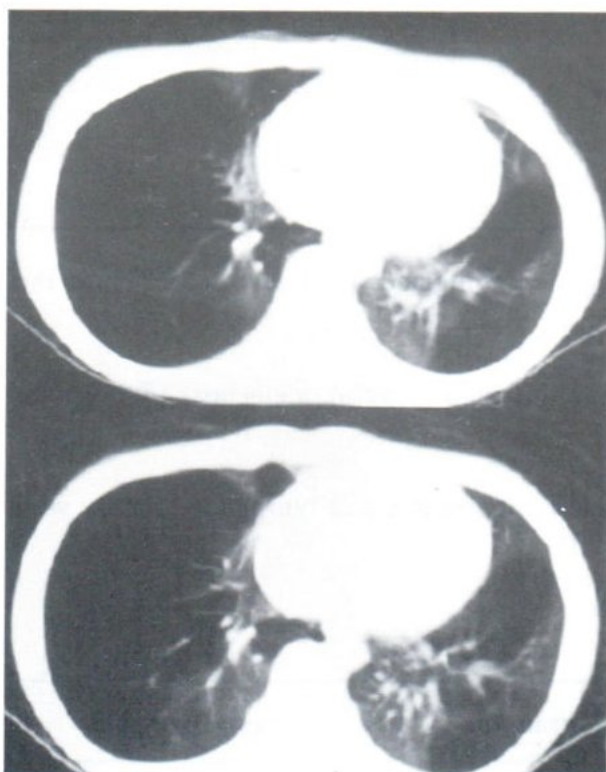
CT scan of the lower chest shows pan-lobular emphysema of the lingular segment of LUL and postero-basal segment of LLL
